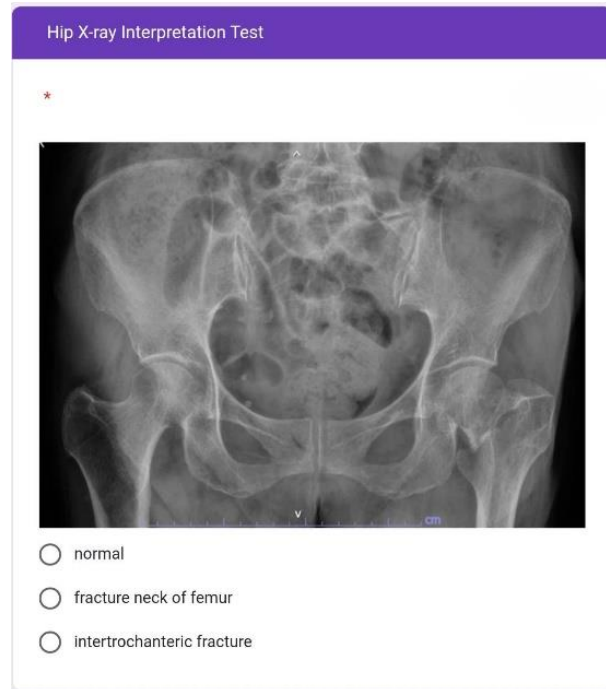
Example of a hip radiograph interpretation assessment utilized in this study. The image demonstrates an anteroposterior view of bilateral hips. Participants were required to classify the radiographic findings into one of three diagnostic categories: normal anatomy, femoral neck fracture, or intertrochanteric fracture.
